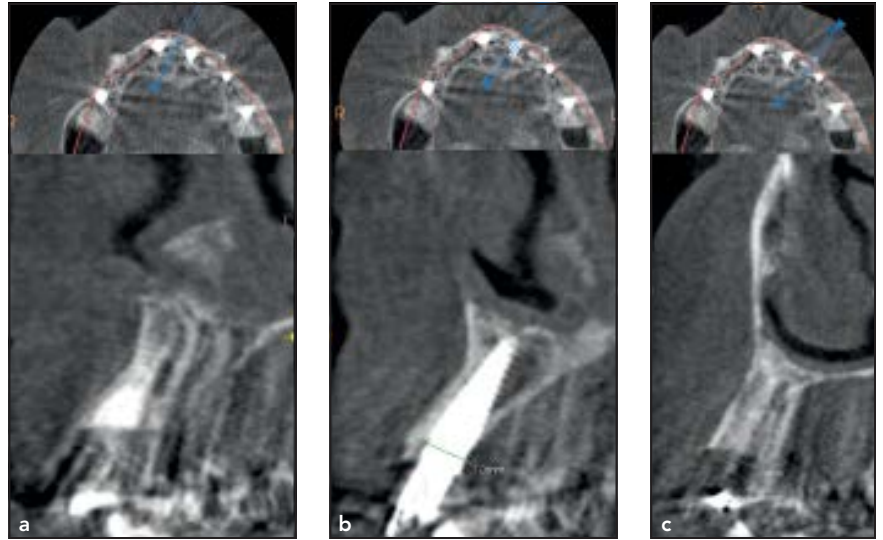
CBCT slices of sites (a) 21, (b) 22, and (c) 23 at the 1-year follow-up.
